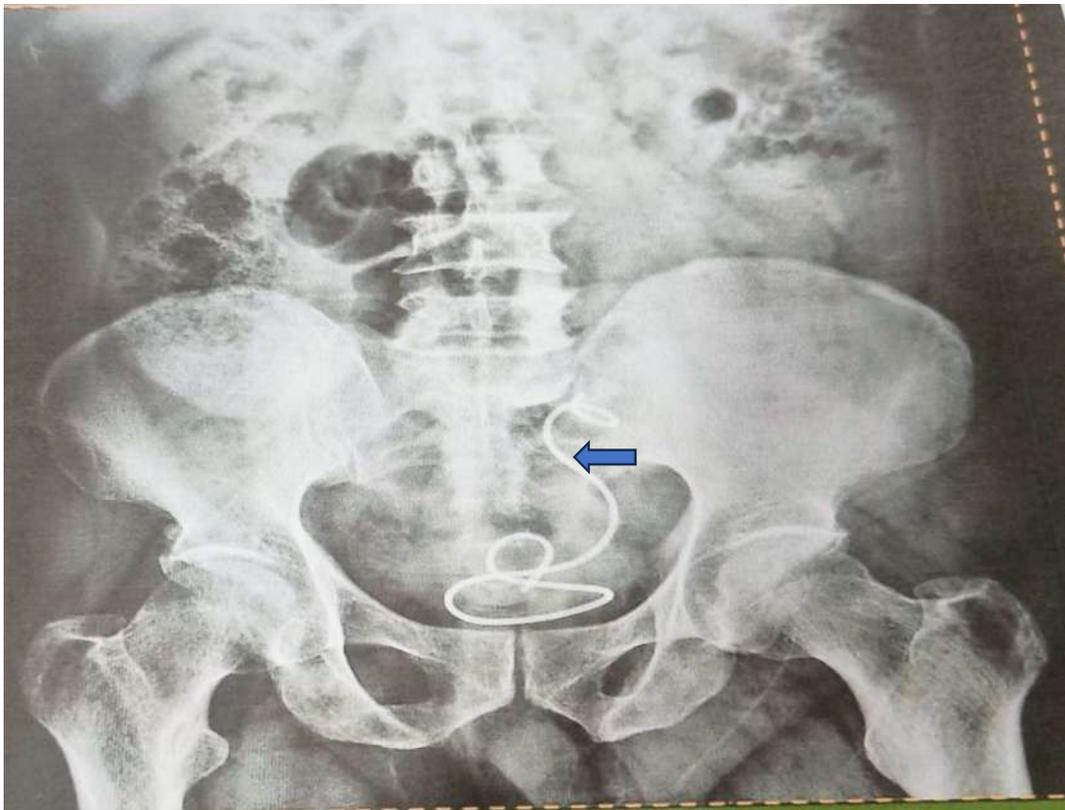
Xray KUB image of the patient showing the retained Double J stent in the left sided ectopic pelvic kidney.
